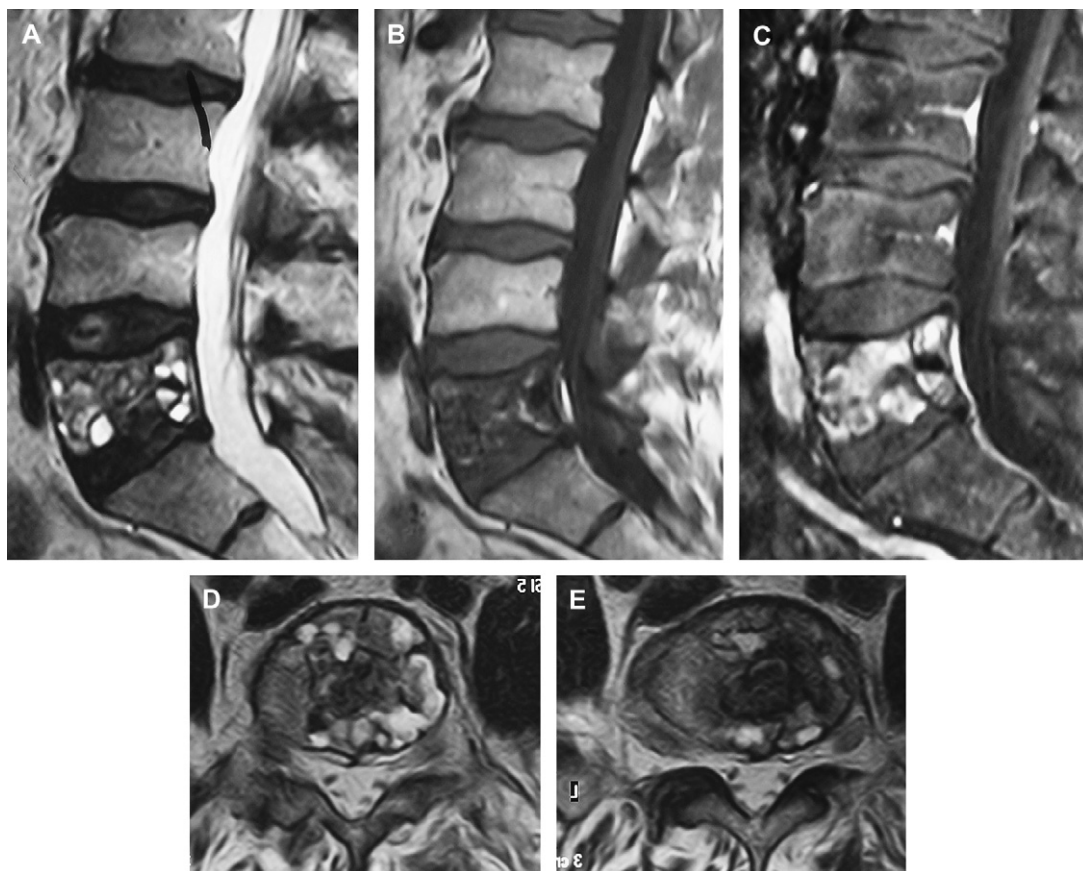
MRI imaging of an L5 ABC showing a cystic lesion with heterogenous signal characteristics and heterogenous contrast enhancement. Fluid–fluid levels are also evident. (A) Sagittal T2 image. (B) Sagittal T1 image. (C) Sagittal T1 with gadolinium image. (D, E) Axial T2 images.
